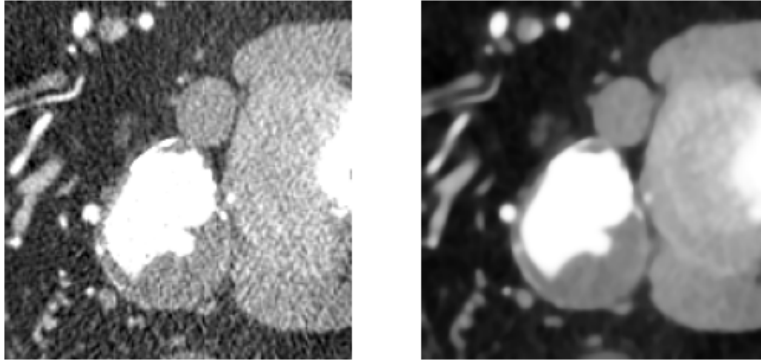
CTA before and after the smoothing. (Patient 1)
